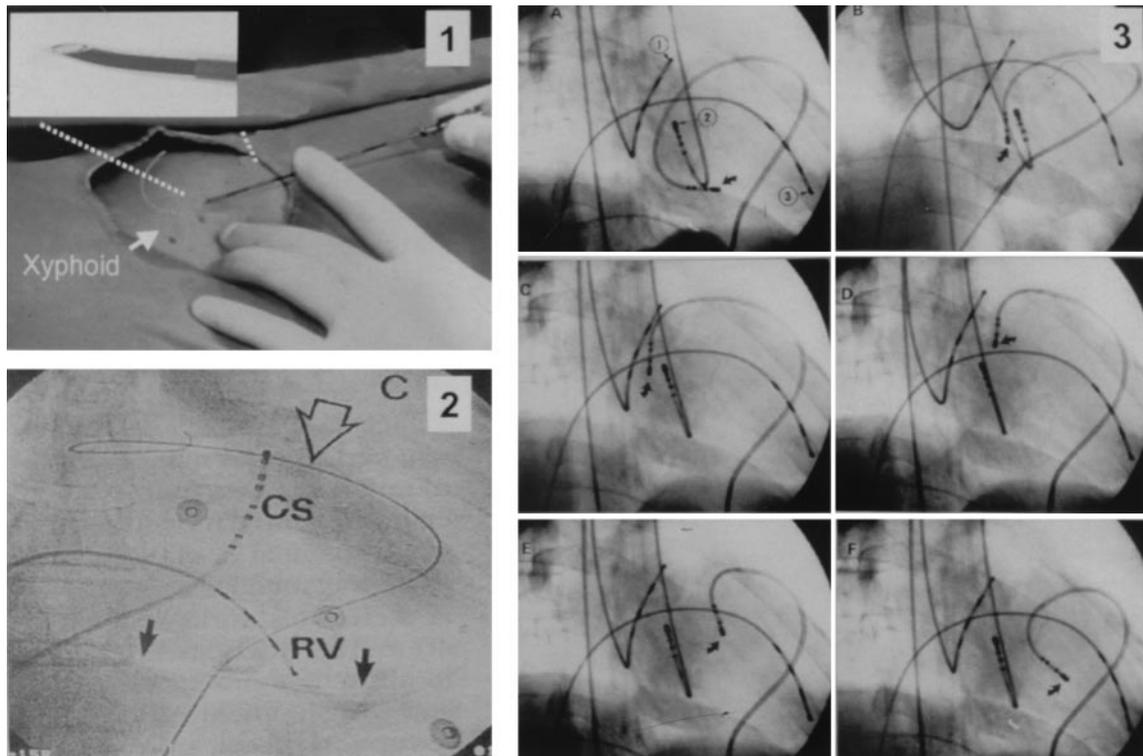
Technique used to insert the mapping and ablation catheter in the pericardial space. The needle used for epidural anesthesia (detailed in the left superior corner) being currently used for transthoracic pericardial puncture, according to the technique described by Kirkorian, to drain epicardial effusions (panel 1). A soft floppy-tip guidewire is introduced into the pericardial space (large arrow), where contrast is also present (black arrows) (panel 2). Then, an 8F introducer is advanced, the guidewire is removed and a quadripolar, 4-mm tip, 7F regular steerable catheter is gently introduced into the pericardial sac to perform epicardial mapping and/or ablation. Panel 3 demonstrates a right anterior oblique view at 60° obtained by fluoroscopy during epicardial mapping procedure. The epicardial catheter (arrow) is manipulated and placed in different locations of the epicardial space (A to F), where epicardial electrograms are obtained. RV = right ventricular apex catheter; CS = coronary sinus; 1 = coronary sinus catheter; 2 = endocardial left ventricular catheter; 3 = right apical endocardial catheter.
